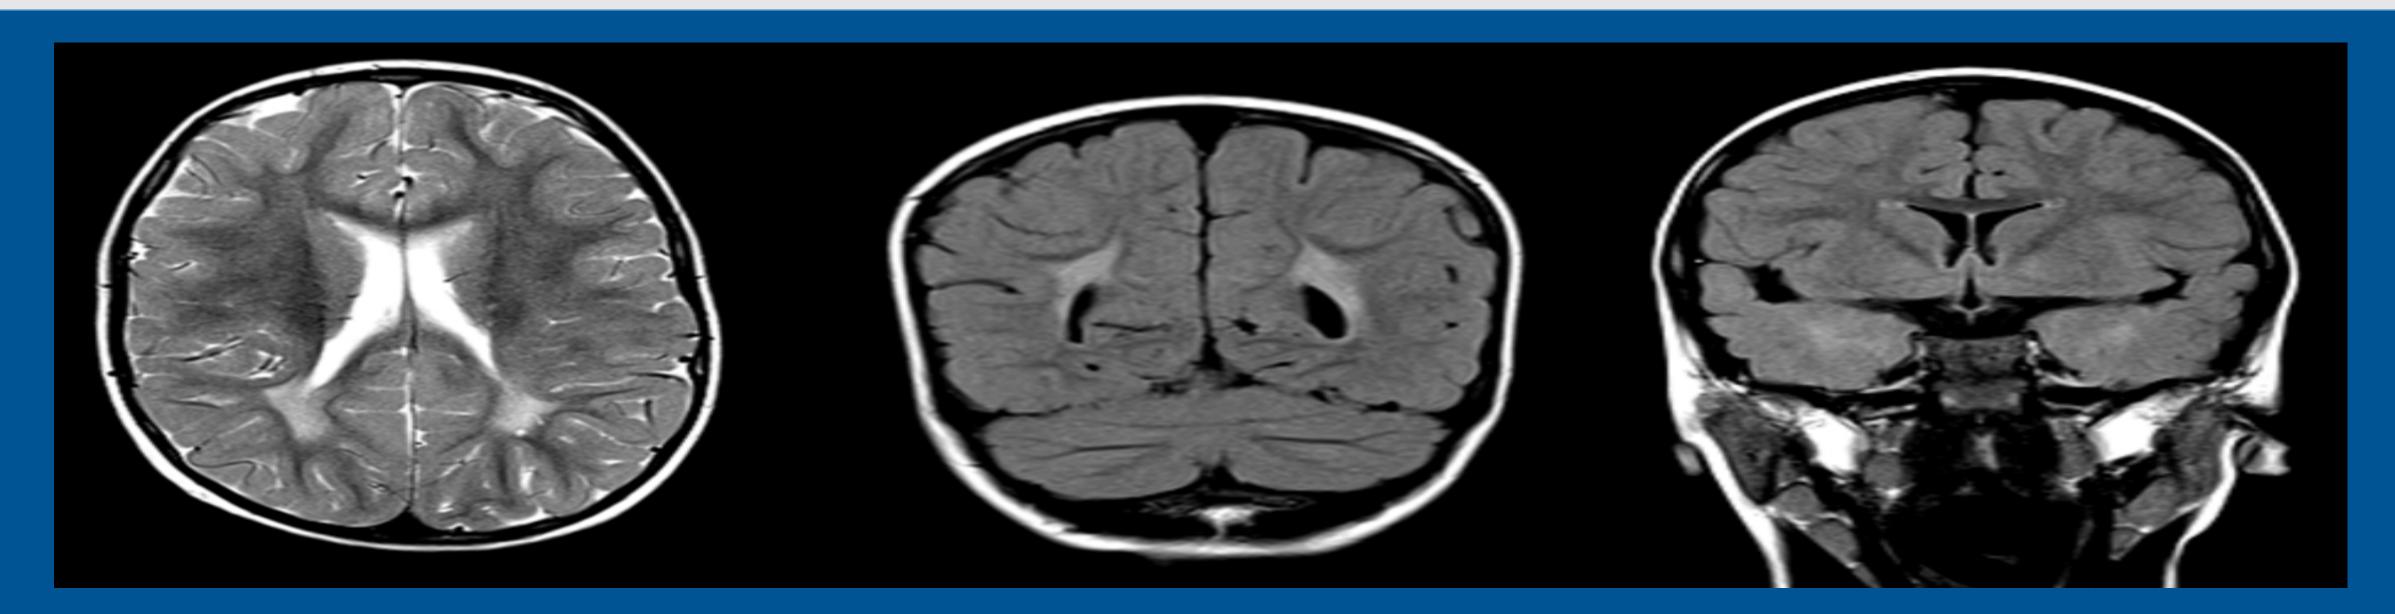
MRI done at 3 years of age
